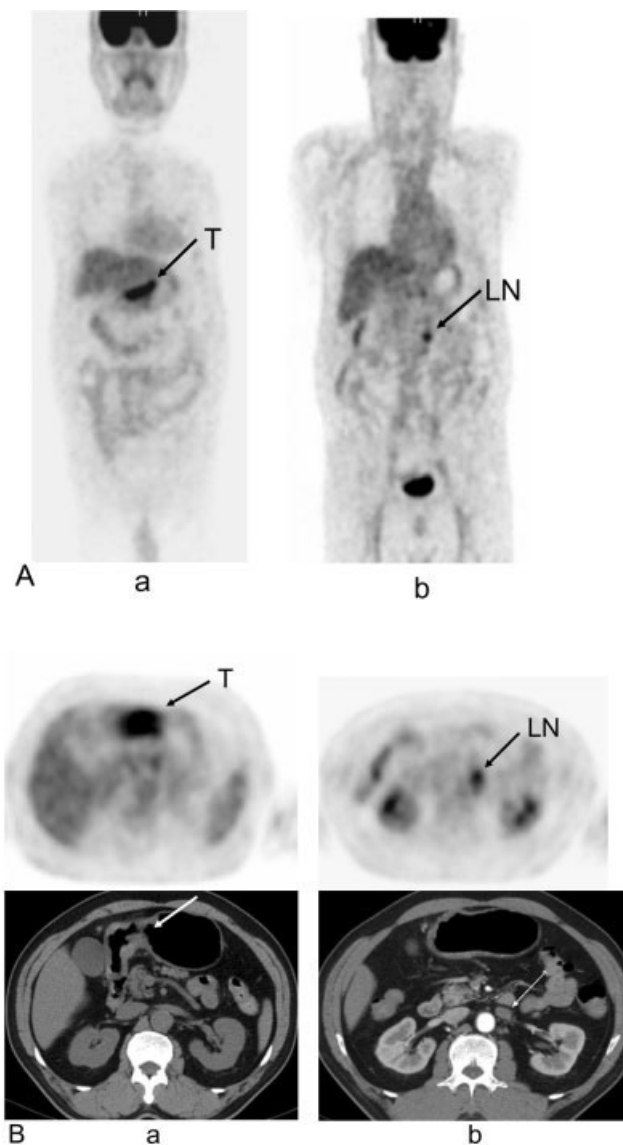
Primary adenocarcinoma of stomach with local lymph node involvement. (A) Coronal PET scan demonstrates a primary tumor (T arrow) and a local lymph node (LN arrow) with increased FDG uptake. (B) Axial PET scan and CT scan demonstrate a primary tumor and a local lymph node (arrows).
